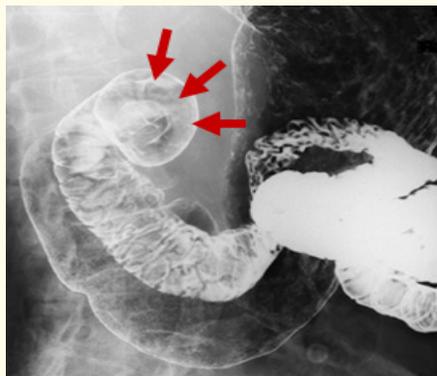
Gastrointestinal Contrast Radiography Revealed Protruded Lesion with Centrally-Depression at the Same Area (See Arrows).
